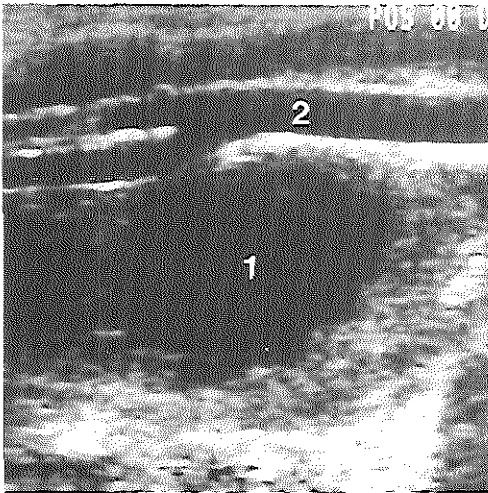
Longitudinal ultrasound view at the level of the carotid artery. A parapharyngeal abscess is shown as an ill-defined, fluid filled structure medial and dorsal to the carotid artery.
